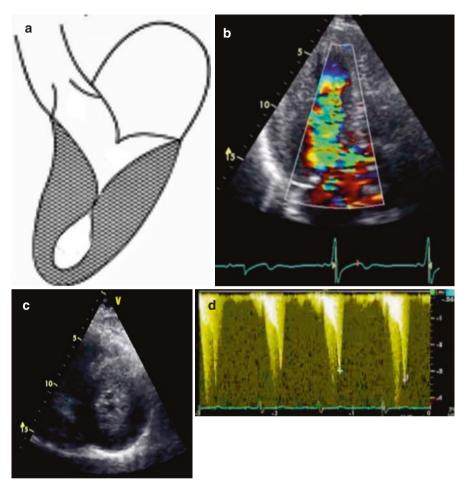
(a) Mid-LV cavity hypertrophy, (b) Turbulent flow in mid-LV cavity in apical 3-chamber view, (c) LV short-axis view with significant hypertrophy, (d) High Doppler Flow gradient in mid-LV cavity
